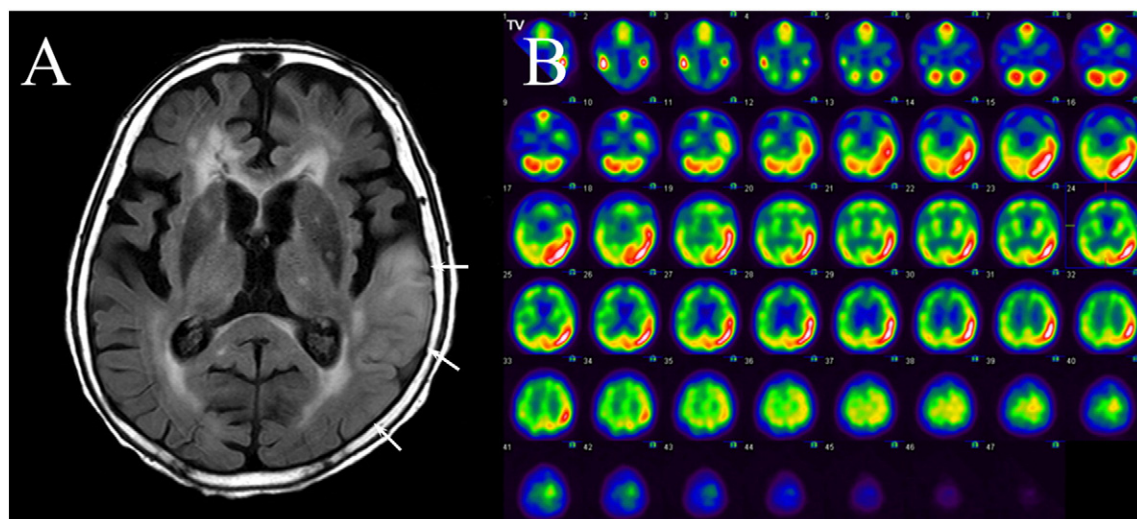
A. Image shows an increased signal intensity in the left temporo-occipital region on fluid attenuated inversion recovery image (arrows). B. Ictal single photon emission computed tomography shows hyperperfusion in the left temporo-parieto-occipital junction.
